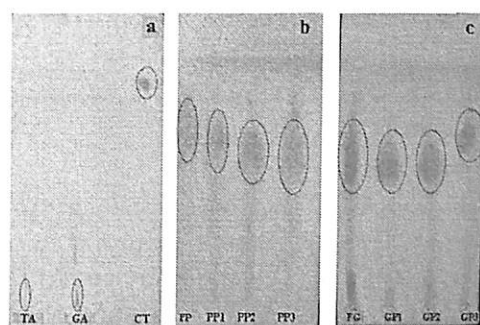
Thin layer chromatogram of fruit juices. FP– fresh pineapple; PP1, PP2 & PP3 – packed juices; FG – fresh guava; GP1, GP2 & GP3 – packed juices; GA – gallic acid; TA – tannic acid; CT – catechin
